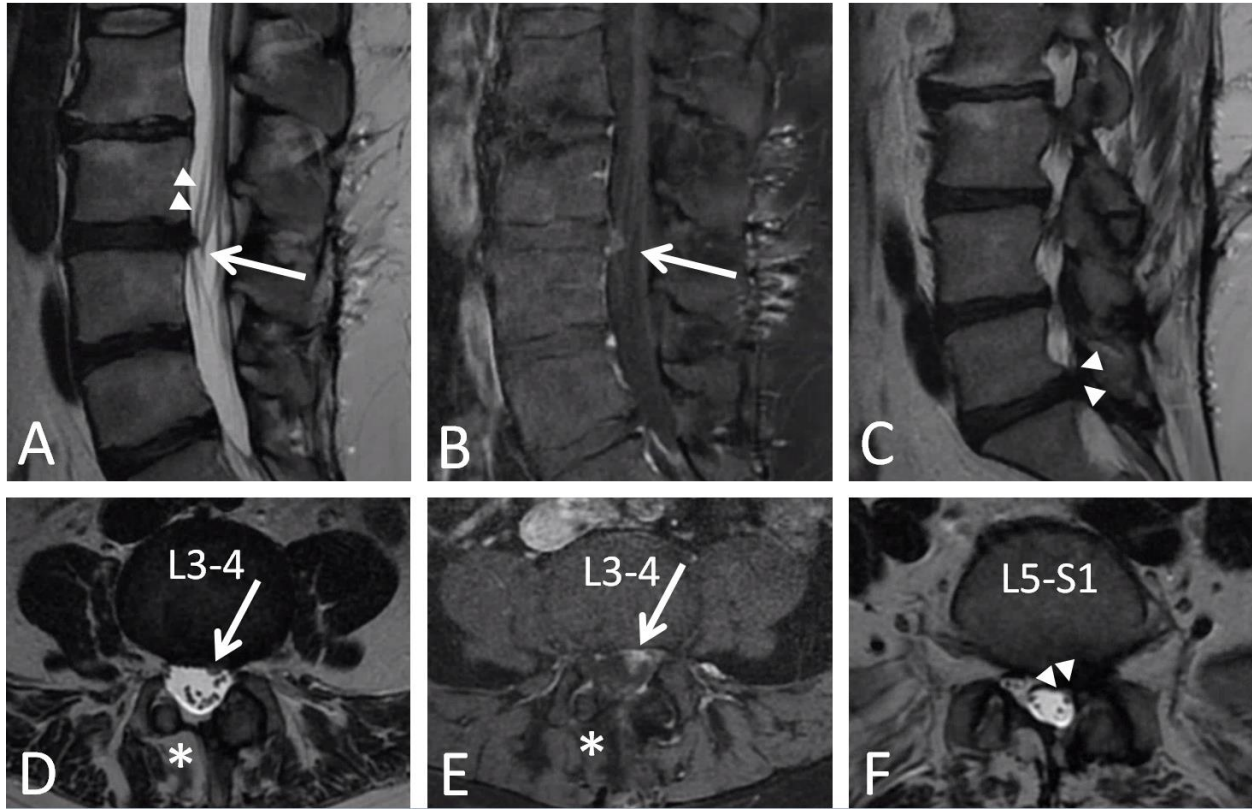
Lumbar spine MRI. Although no epidural abscess is seen, sagittal (A) and axial (B) T2 weighted sequences demonstrate a T2 hypointense, nodular region of soft tissue extending from the left paracentral anterior epidural space at the level of the L3-L4 intervertebral disc space (arrows). The mass appears contiguous with the traversing left S1 nerve roots, which are displaced/clumped anteriorly (arrowheads in A). Superimposed enhancement on T1-weighted post-gadolinium sequences (sagittal in B, axial in A, arrows), raises suspicion for scar/granulation tissue, potentially related to prior right L4 hemilaminectomy (demarcated by the asterisk in D-E). Additional region of suspected contact of the traversing left S1 nerve roots identified on T2 weighted sequences (sagittal in C and axial in F) by a paracentral disc osteophyte complex at L5-S1 (arrowheads in C and F).
